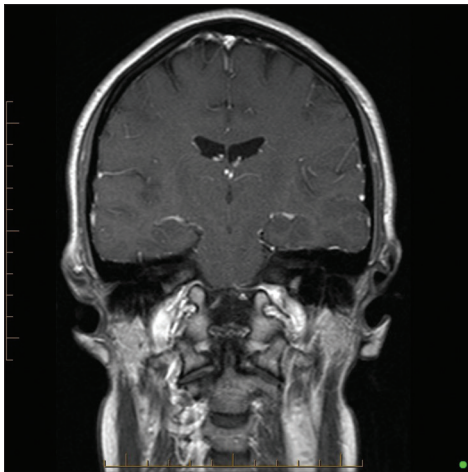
T1-weight coronal magnetic resonance imaging head postgadolinium posttreatment with resolution of the dural enhancement
